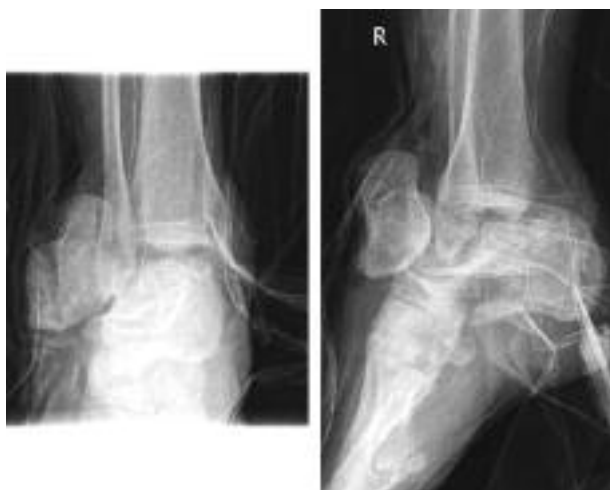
Case 1 : initial radiograph
